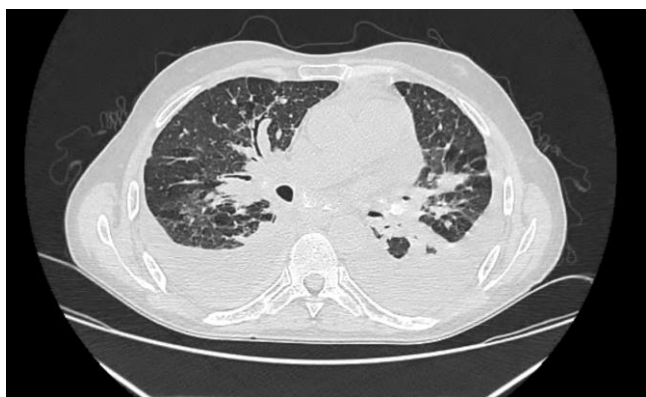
Thoracic CT, parenchymal section of multiple pulmonary nodules and micronodules
